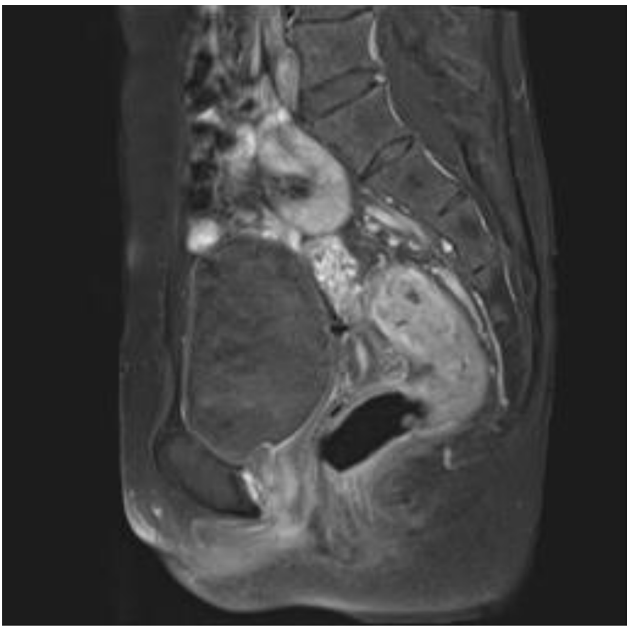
Enhanced T1-weighted MRI (sagittal view) showing sigmoid-rectal wall thickening and lumen stenosis in a 50-year-old female
